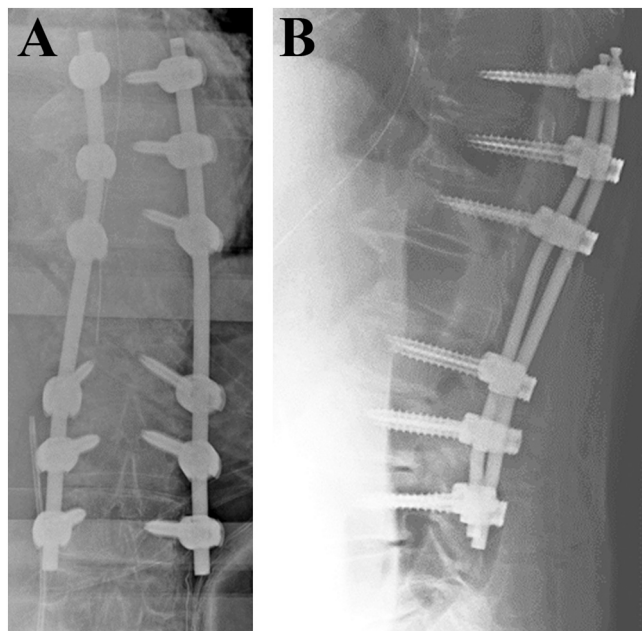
Postoperative X-rays show good reduction of the T12 fracture and posterior fusion from T9 to L3.
